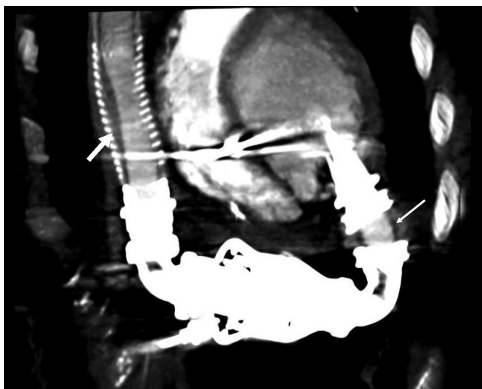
Chest computed tomographic image of left ventricular assist device thrombus in patient 2. Coronal view demonstrating thrombus in the inflow cannula (thin arrow) and outflow cannula (thick arrow).
